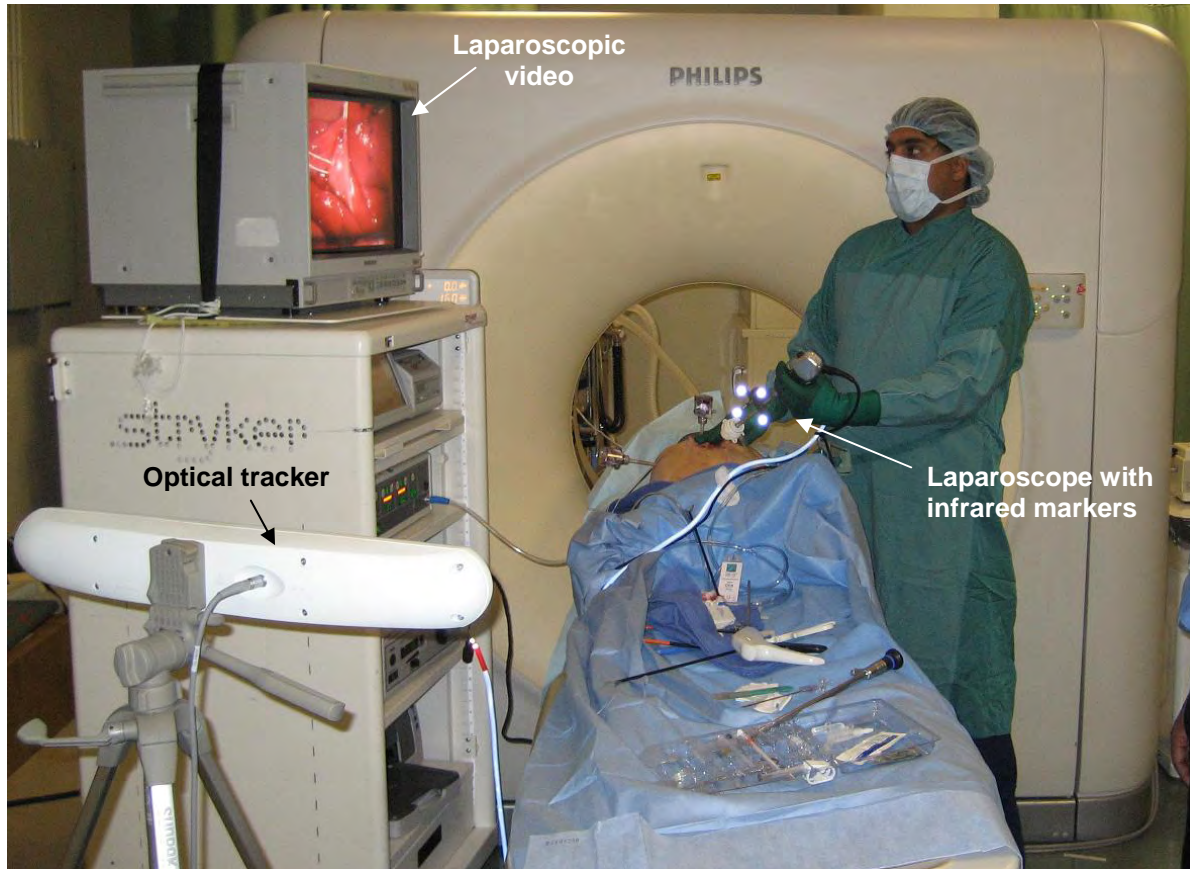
The setup for CT-guided minimally invasive laparoscopic surgery. The laparoscope is tracked using an optical tracker. The AR views, in this preliminary study, were created in an offline fashion.
